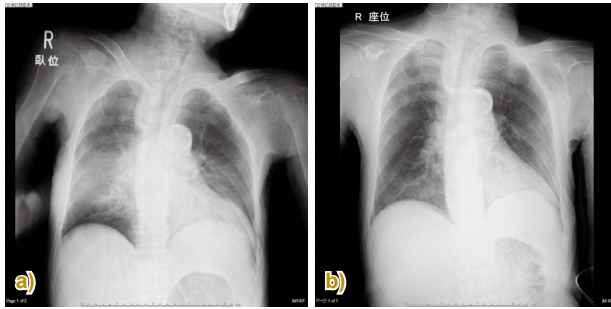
a) Chest X-ray image. b) Chest X-ray image of the same patient from the previous day.
